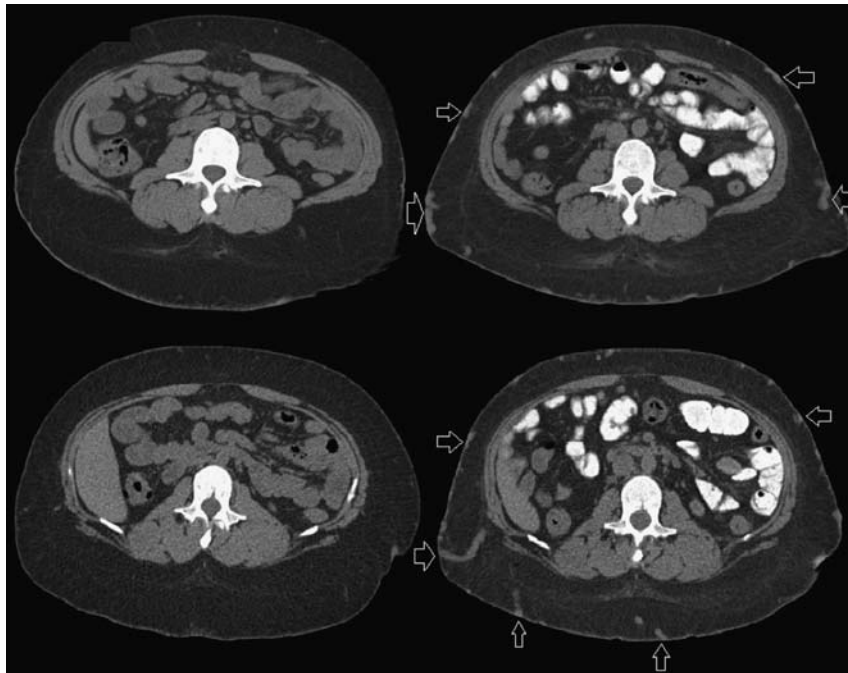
CT imaging pretransplant and posttransplant demonstrating development of extensive venous collaterals. Axial CT pretransplant (left images) demonstrating normal-appearing subcutaneous fat with absent collateral veins. Axial CT 5 months posttransplant (right images) demonstrating innumerable tortuous collateral veins in the subcutaneous fat (open white arrows delineating representative examples), formed because of the underlying inferior vena occlusion.
